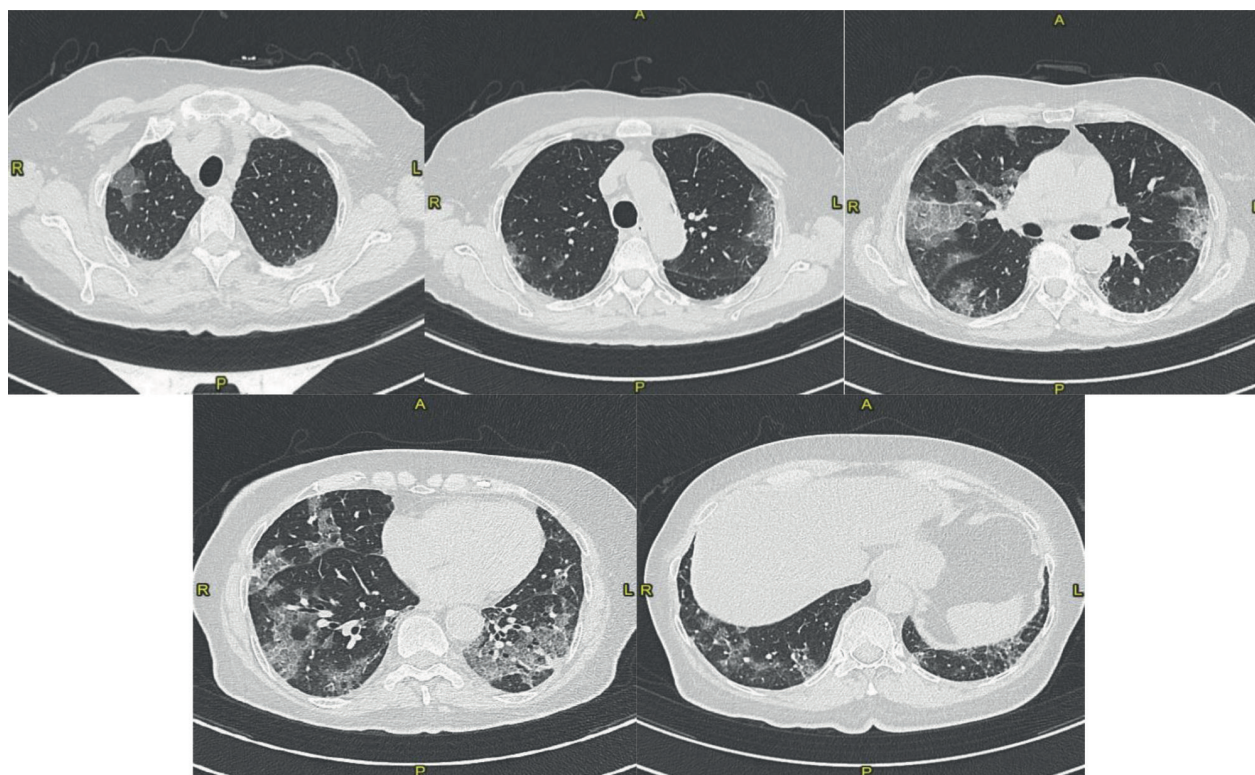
CT at the 1st hospitalization (March 2020): Bilateral ground glass opacities with patchy distribution - visual score of 35%.
